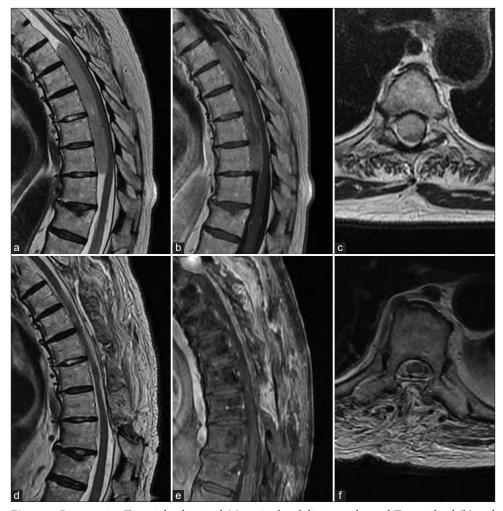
Preoperative T2-weighted sagittal (a), sagittal gadolinium-enhanced T1-weighted (b) and T2-weighted axial (c) MRI showing a stretched and fusiform intradural extramedullary lesion at T5-T10 level about 13 cm long in craniocaudal direction. Postoperative T2-weighted sagittal (d), sagittal gadolinium-enhanced T1-weighted (e) and T2-weighted axial (f) MRI showing complete resection of the mass lesion.
